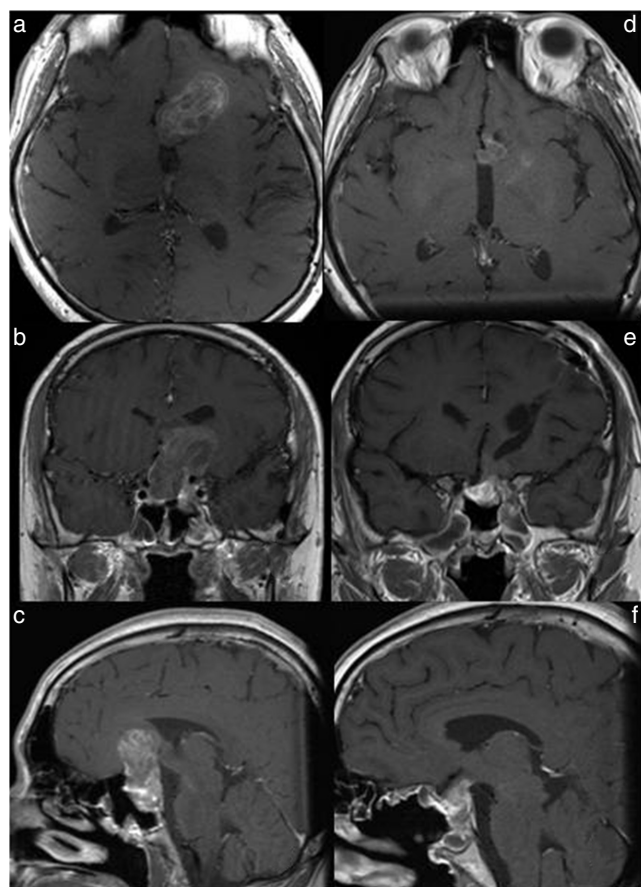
a–c: Pre- and postoperative MRI scans. Maximum diameter of the tumor was 47 mm on preoperative MRI. d–f: The tumor was buried inside the frontal lobe. The tumor was sub-totally removed. MRI: magnetic resonance imaging.
